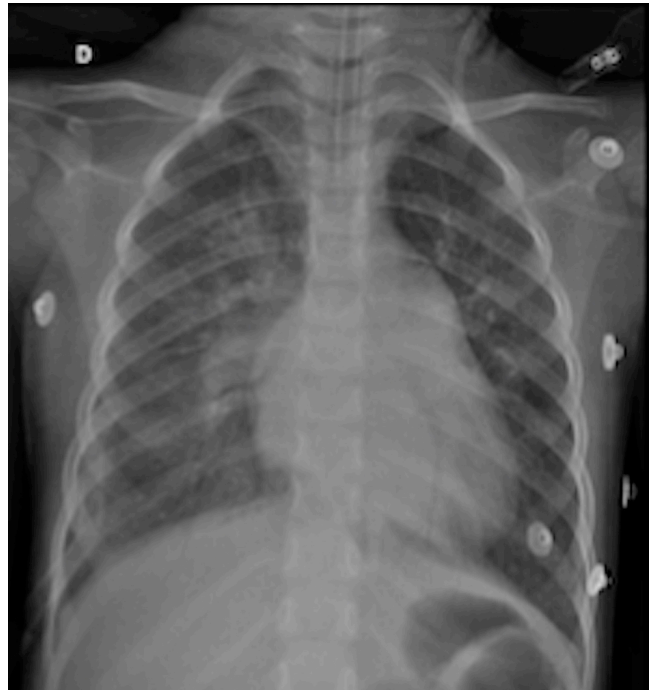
Chest radiograph 5 hours after surgery showing the interstitial bilateral infiltrates
